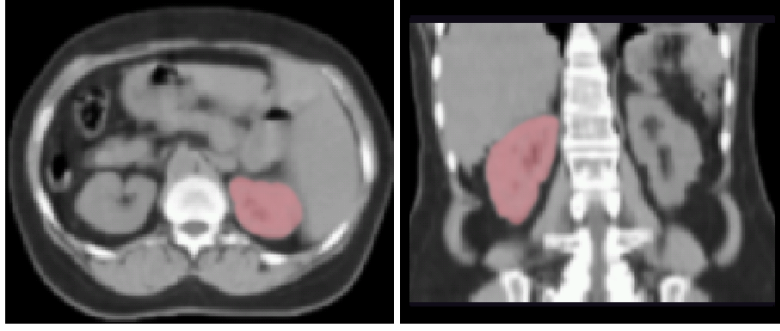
The right kidney highlighted in both axial (left) and coronal CT slices. Note the variable intensity pattern with respect to the kidney.
